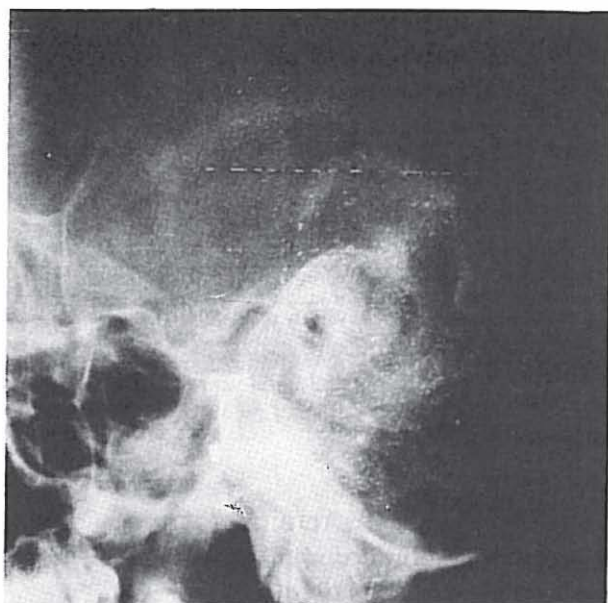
Mastoid x-ray from case 1.
